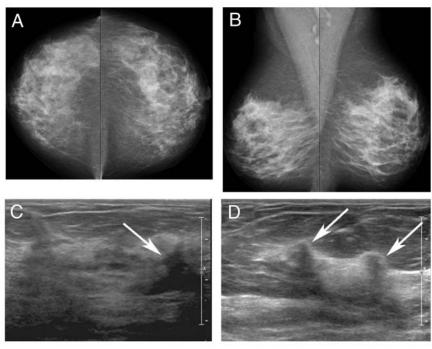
Images of a 54-year-old asymptomatic woman with dense breast tissue and no history of breast cancer: A. craniocaudal digital mammogram; B. mediolateral oblique digital mammogram; C. transverse sonogram of the right breast, showing 7 mm, grade 1, stage 1 invasive ductal carcinoma (arrow); D. sonogram of the left breast, with arrows indicating 10 mm, grade 1, stage 1 invasive carcinoma with lobular carcinoma in situ. Images courtesy of Dr Kevin Kelly.
